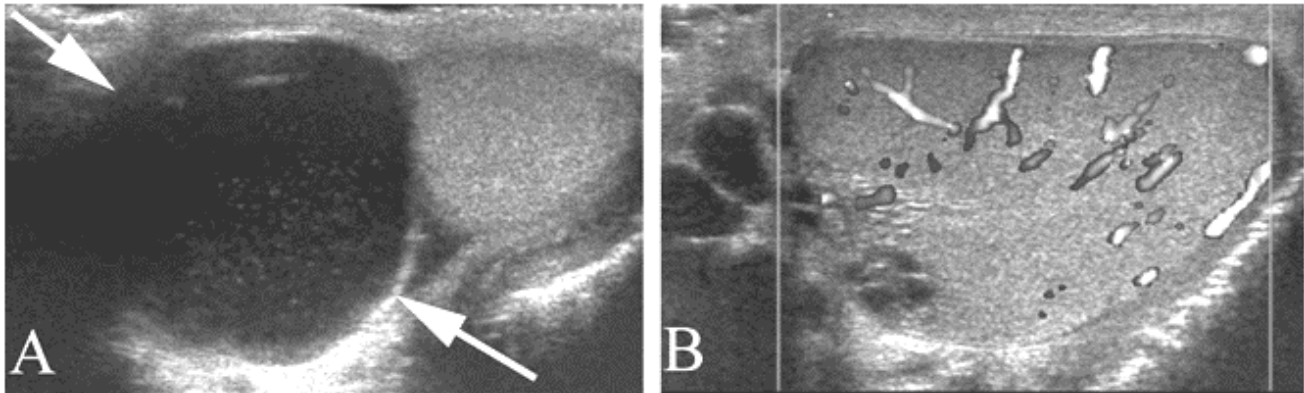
Epididymal cyst/spermatocele in a 46 year old with a painless mass in the left scrotum. A. Large spermatocele (arrow) adjacent to the (much smaller) testicle. B. Color Doppler of the normal adjacent ipsilateral testicle, with normal flow.
